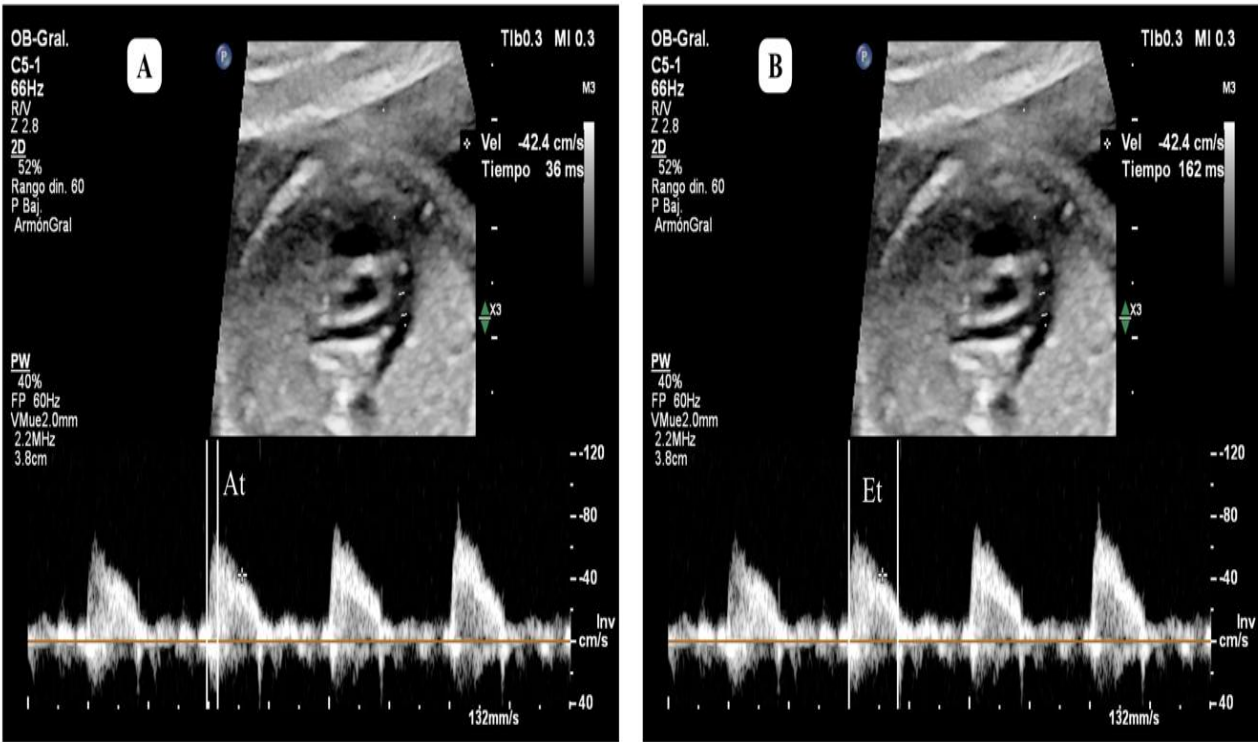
Spectral Doppler waveform analysis of the fetal main pulmonary artery; (A) measurement of the acceleration time (AT). Calipers are placed from the onset of the systolic flow to the point of peak systolic velocity (recorded as 36 ms). (B) Measurement of the Ejection Time (ET). Calipers are placed from the onset of the systolic flow to the end of the forward ventricular ejection, where the waveform returns to the baseline (recorded as 162 ms). Note the use of a high sweep speed (132 mm/s) to stretch the waveform horizontally, allowing for highly precise temporal caliper placement. For this specific cardiac cycle, the calculated AT/ET ratio is 0.22
